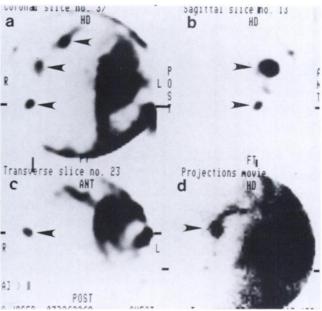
SPECT images (a: coronal, b: sagittal, c: transverse, d: projection) identify several foci of increased activity in the right lateral chest wall (arrows), consistent with active bleeding.
